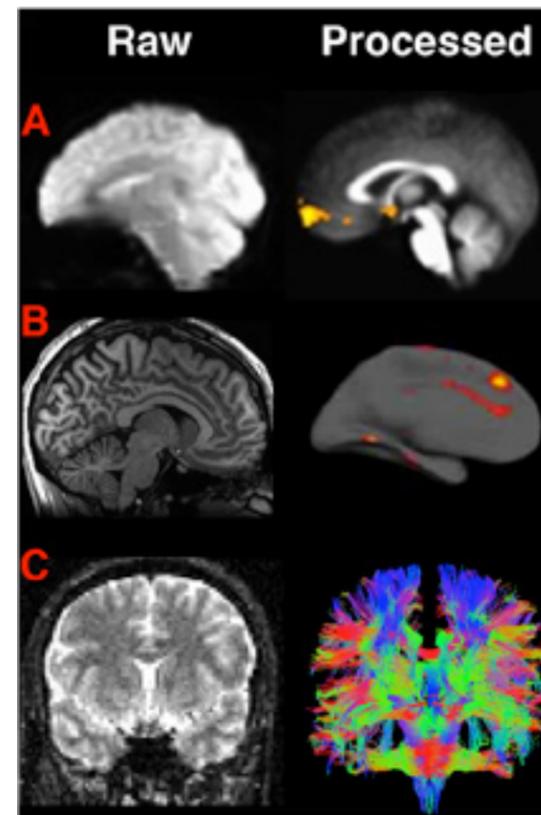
Different MRI modalities. detailed explanation at end of article
